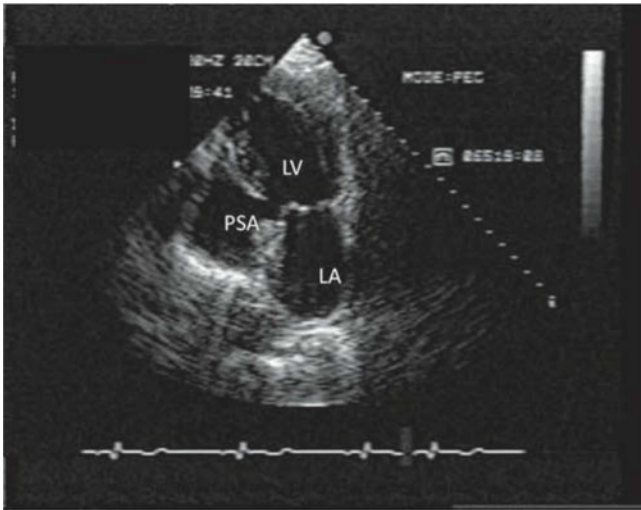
Apical two-chamber view of a transthoracic two-dimensional echocardiogram in a 55-year-old man who collapsed 6 months after inferior MI. The image shows a left ventricular free wall rupture resulting in pseudoaneurysm (PSA) communicating with the left ventricle (LV). LA, Left atrium.
